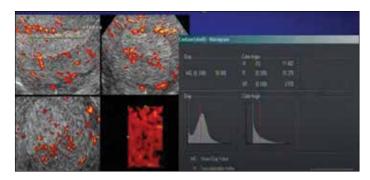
3D Power Doppler Rendering and quantification showing 3 indices, i.e., flow index, vascularization index, and vascularization flow index
